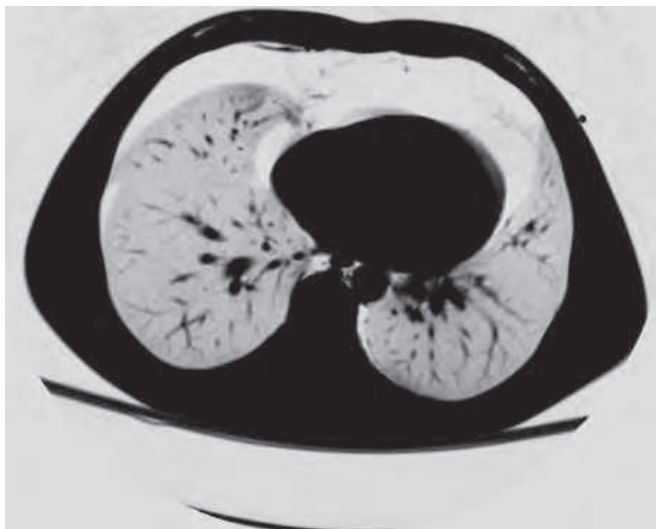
CT scan chest showing bilateral pneumothorax in a patient with intrathoracic airway injury
